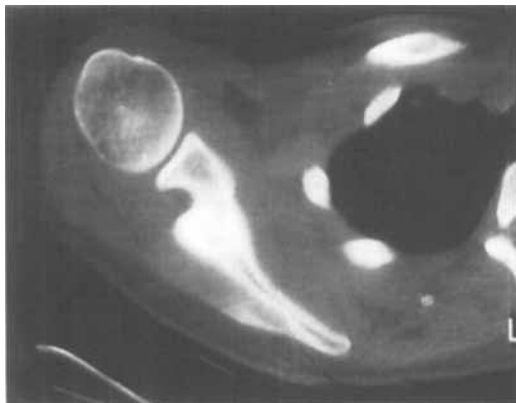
CT scan after complete excision of the osteochondroma.
